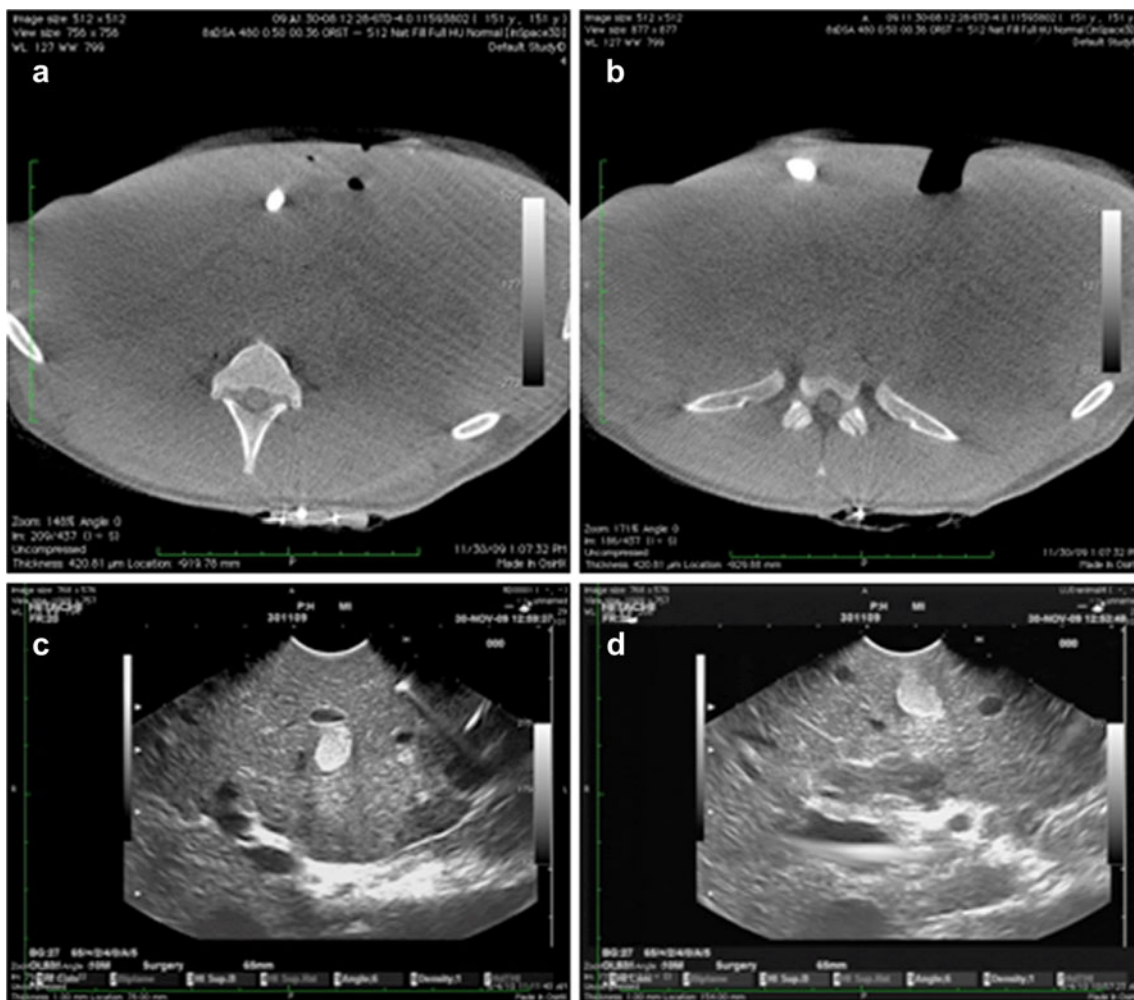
Sample images of in vivo model tumors. a, b Computed tomography slices showing two model tumors. c, d The corresponding tumors seen in laparoscopic ultrasound images.
